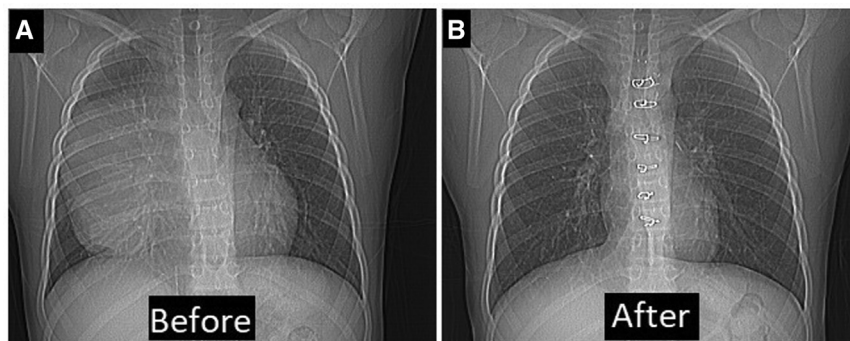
Radiographic images showing (A) before and (B) after surgical removal of the tumor.
